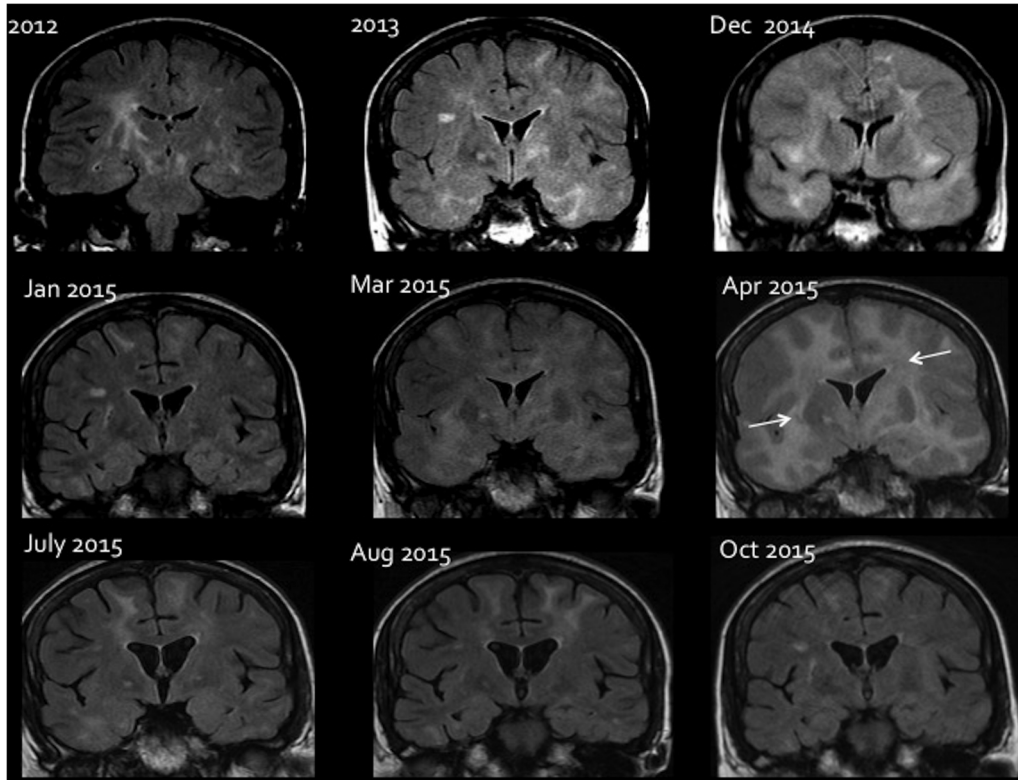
Sequential MRI changes during treatment of CD8+E. Coronal FLAIR images showing the brain parenchymal changes and response to different treatment. In 2012, an abnormal high signal is seen in the basal ganglia bilaterally with signal change in the white matter in keeping with encephalitis. Image taken from 2013 shows a marked worsening of white matter signal change more extensive within the temporal lobes. In 2014, there is a bilateral white matter signal change with diffuse brain swelling and effacement of all cortical sulci. Following steroid initiation in December 2014, there is significant improvement in the signal change as well as mass effect on the January 2015 image. A worsening in March 2015 and a more pronounced deterioration in April 2015 (arrows), after reduction in steroids. A subsequent increase in steroids shows a remarkable improvement in July 2015. The patient was later started on mycophenolate mofetil in July 2015; this allowed a further amelioration of lesions as seen in August 2015 and October 2015, despite a tapering of steroids.
